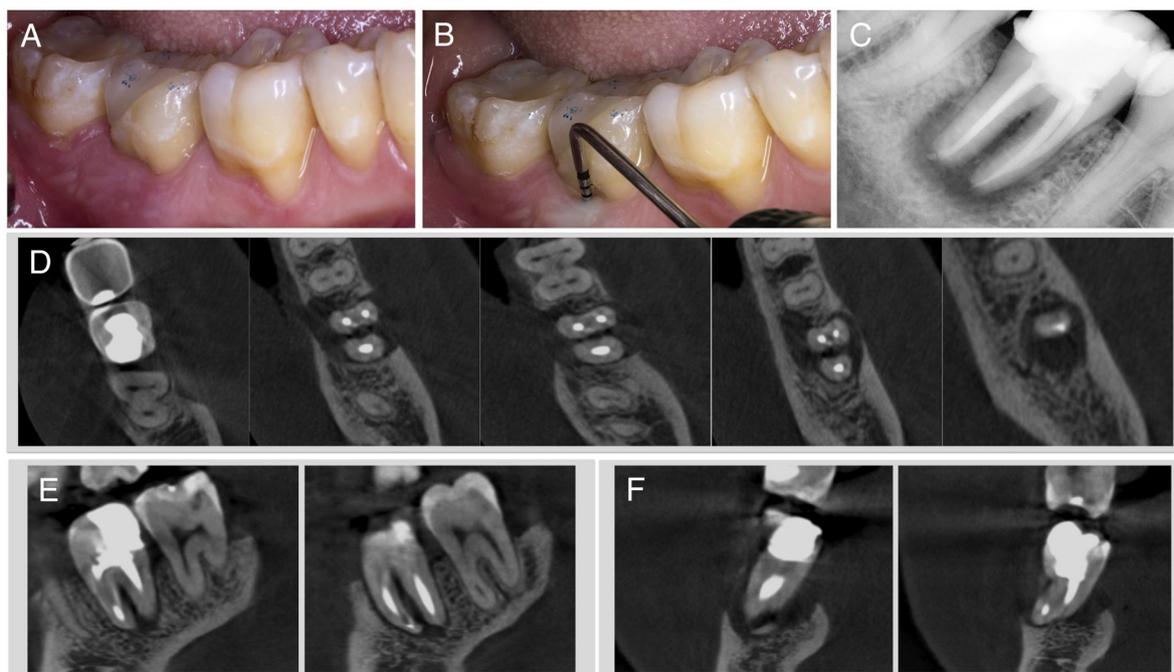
(A) A 35-year-old woman was referred for evaluation of her mandibular right second molar (tooth #31). (B) Periodontal probing revealed local pocketing almost to the apex on the mesiobuccal and distobuccal region of tooth #31. (C) Tooth #31 with endodontic treatment and clinical signs of VRF. Note the extensive furcation, crestal, and periapical bone resorption. (D) The reconstructed axial CBCT (Planmeca 3Ds) images showed an extensive bone resorption in the buccal and lingual surface. (E) The sagittal view. (F) Coronal CBCT images revealed a complete loss of the buccal cortical plate of tooth #31. The fracture was not visible on either imaging modality.
